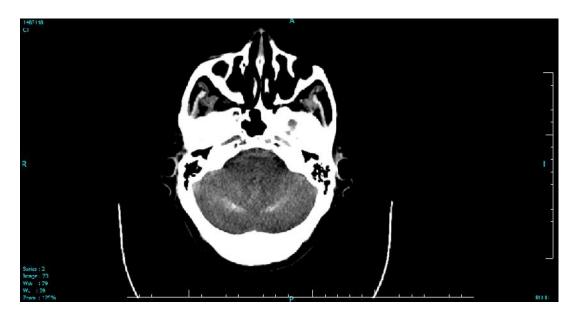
Computed tomography scan of the brain showing bilateral cerebellar calcifications
